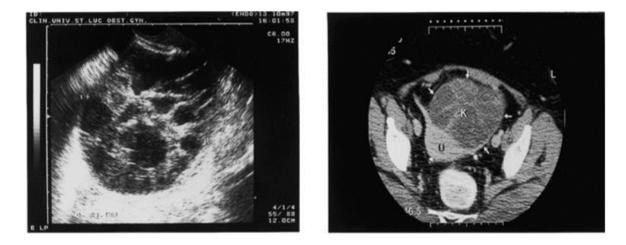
(Left) Computed tomography: Rectal Adenocarcinoma (arrows). (Right) Transposed ovary: Evidence of Follicular development (F) after pelvic radiotherapy (arrows).
